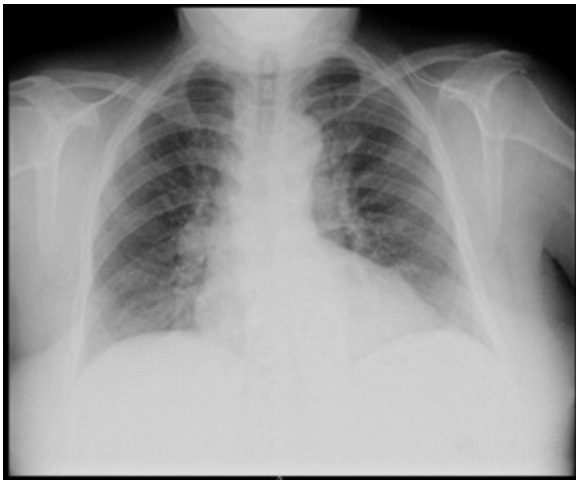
No pneumoperitoneum is visible in thorax X-ray.
